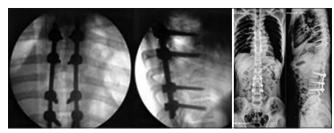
Postoperative X-ray postdecompression X-ray spine anteroposterior and lateral views showing pedicle screws inserted from D6 to D10 and L2-L4 vertebral levels sparing involved D8 vertebra.
